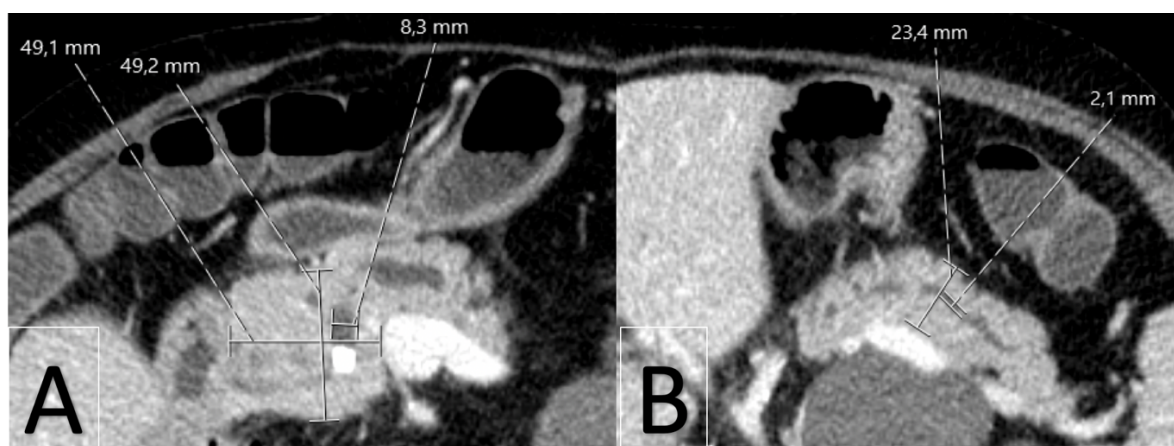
Examples of preprocedural CT imaging with measurements of gland thickness and MPD in A) Head of pancreas and B) Tail of pancreas
